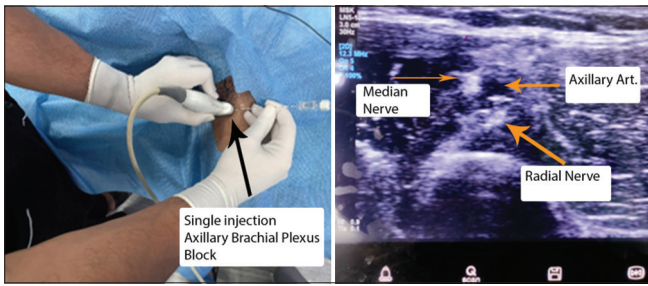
Probe position and corresponding sonographic view during Axillary brachial plexus block. The probe was positioned in the short axis orientation to identify the axillary artery about 1–3 cm from skin surface. 8 mL of local anesthetic was deposited posterior to the artery for radial nerve and 12 mL was injected around median and ulnar nerves after redirecting the needle tip
